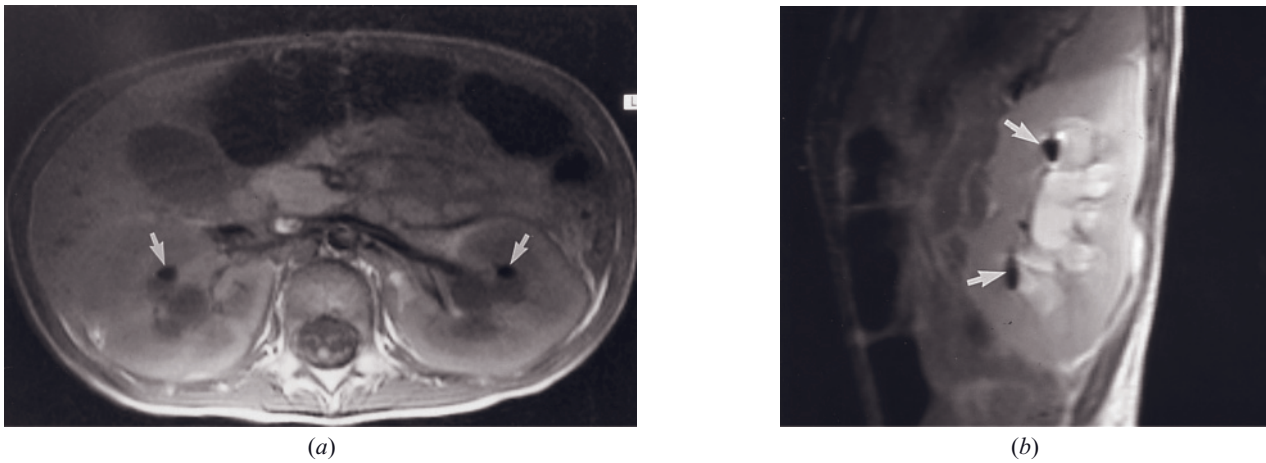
Acute obstruction. Transverse T1-weighted precontrast SE (a) and sagittal T1-weighted gadolinium-enhanced SE (b) images. The kidneys are enlarged in a globular fashion. Corticomedullary differentiation is preserved, reflecting the acuteness of the obstruction (a). Gadolinium excreted into the collecting system is dilute and high in signal intensity (b). Signal-void foci located in the nondependent portions of the renal collecting system demonstrate blooming artifact (arrows, a, b) that represents air introduced by Foley catheterization.
